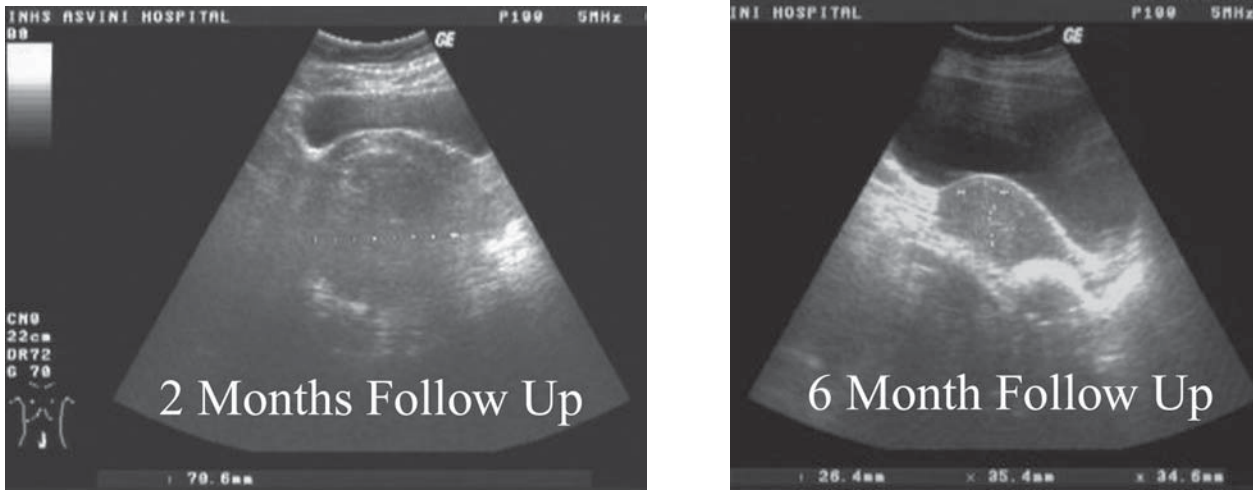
Uterine Artery Embolisation for Uterine Fibroids : long-term follow up ultrasonography showing regression of fibroid lesion
